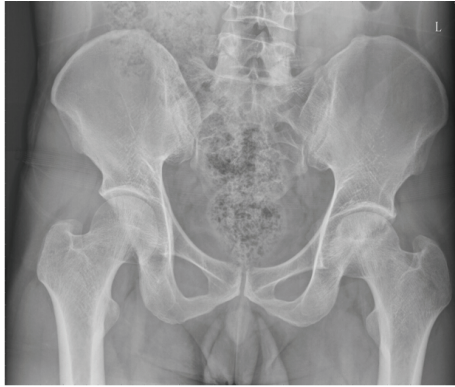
X-ray picture of normal position of pelvis (before surgery).
